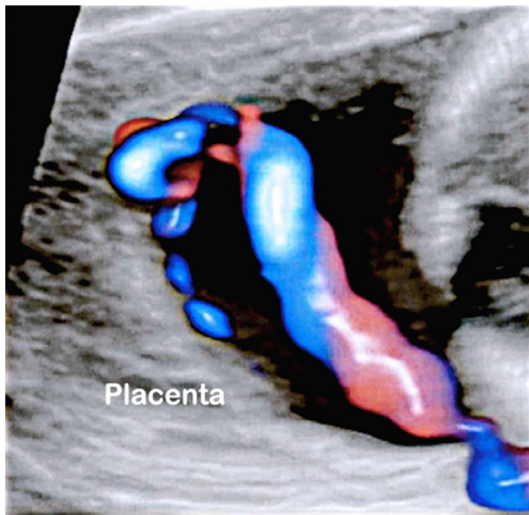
(A, B) Marginal cord insertion (MCI) at 12 and 15 weeks' gestation. 2D ultrasound and color Doppler show the umbilical cord insertion-placental edge distance of a few millimeters at 12 weeks' gestation. (C, D) Color Doppler and 3D ultrasound with "glass body" rendering display the umbilical cord insertion-placental edge distance of more than 1 cm. MCI is characterized by a normal umbilical cord morphology with preserved coverage of umbilical vessels but with a cord insertion into the periphery of the placental disk, typically less than 2 cm from the edge. Asterisk, cord insertion site; arrows, umbilical cord.
